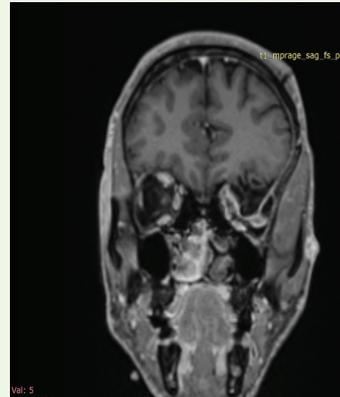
MRI brain, post contrast coronal T1 FS-weighted image OF 39-YEAR-OLD GENTLEMAN WITH KNOWN NF-1 demonstrates herniation of brain parenchyma and cerebrospinal fluid into the superior aspect of the left orbit, consistent with a left orbital encephalocele, resulting in left-sided proptosis.
